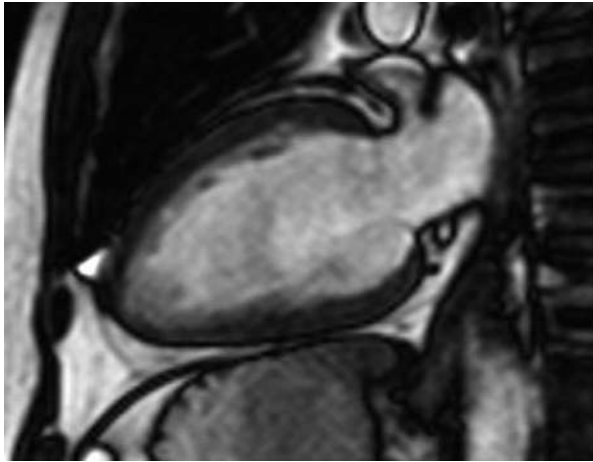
Cine MRI: vertical long axis view of the left ventricle. The left ventricular cavity shows high signal without use of contrast medium, providing a clear delineation of the border with the myocardium.
